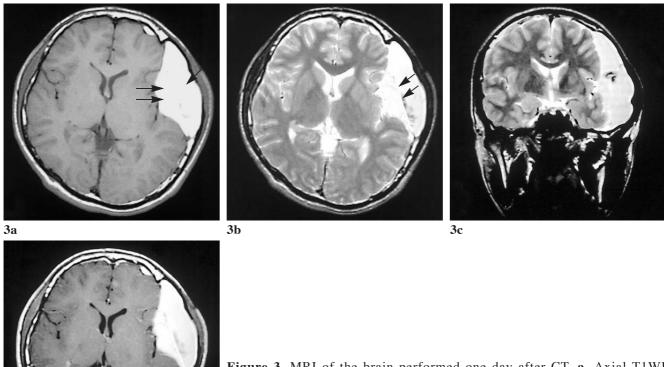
MRI of the brain performed one day after CT. a. Axial T1WI (TR/TE: 466/14 msec) showed hyperintensity of the hematoma (arrow). b. Axial and c. coronal T2WI (4500/75 msec) showed the high signal intensity of the hematoma, which indicated a subacute hematoma. The findings were consistent with hyperdensity of the hematoma on CT. The medial wall of the arachnoid cyst was also observed (double arrows, a and b). d. Axial post-contrast T1WI showed no abnormal enhancement adjacent to the hematoma.
